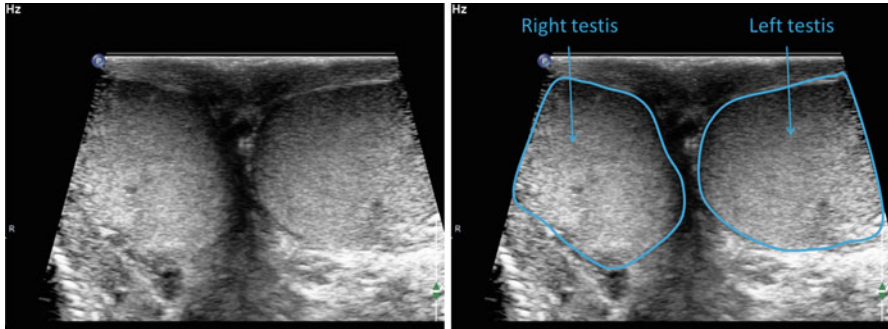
Ultrasound of both right and left testes in adult male. The testes are located outside the body cavity in the scrotum to maintain a lower temperature and promote spermatogenesis
